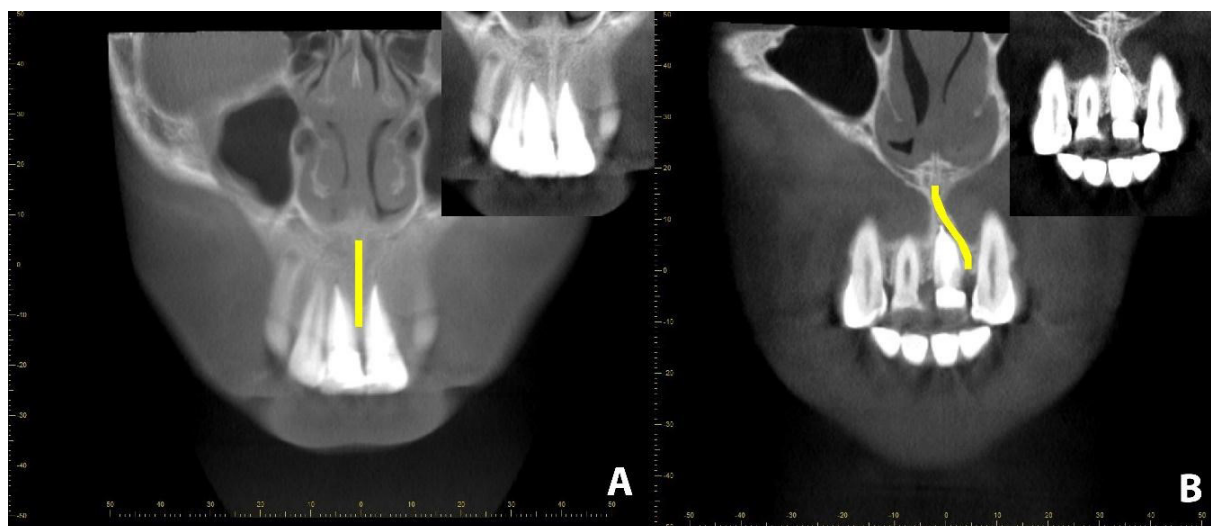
CBCT of the palatine suture A before treatment B after treatment
